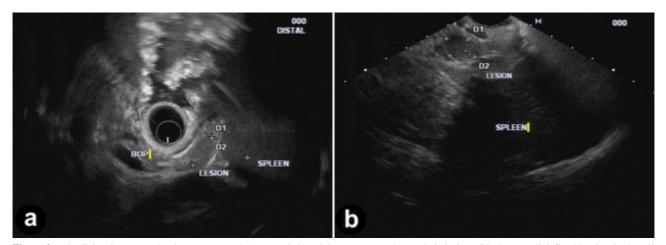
a. Radial endosonography demonstrates a 1.5 cm, oval shaped, homogeneous, hypoechoic lesion with sharp, well defined borders in the tail of the pancreas and has similar echogenicity of the spleen. b. Linear endosonography confirms the same 1.5 cm hypoechoic lesion for fine needle aspiration.
